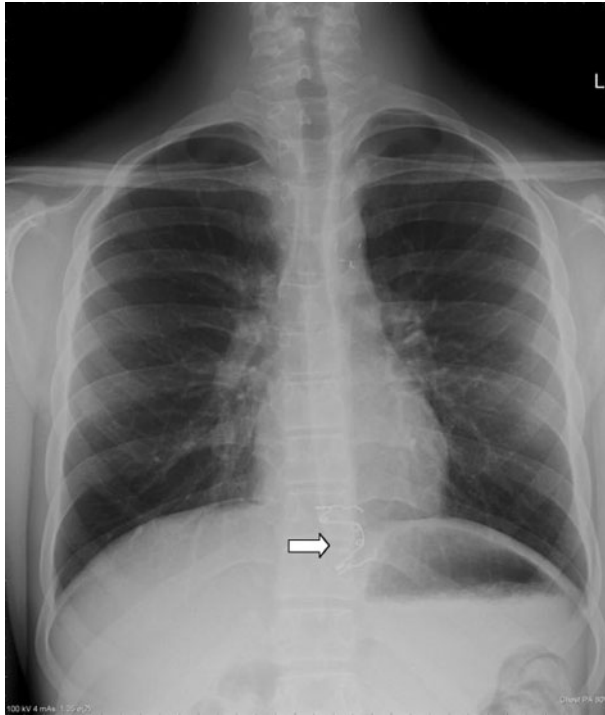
Chest radiograph showing quadhelix (white arrow head) in the lower oesophagus
